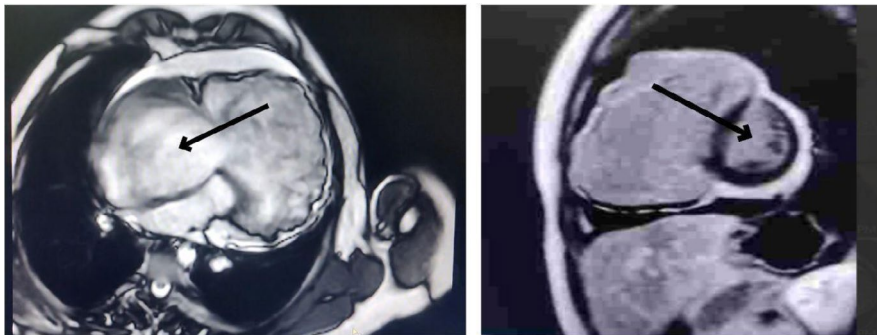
Cardiac MRI showing Aneurysmal dilated right sided cardiac chambers with dyssynchronous right ventricular (RV) wall motion. Arrow showing dilated RV with aneurysm.
